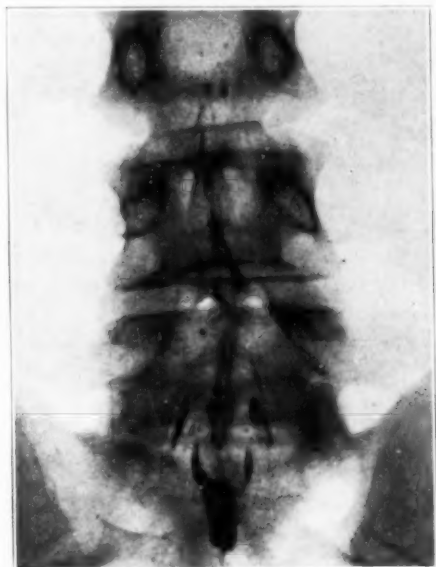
Neuritis of the cauda equina. Roentgenographic appearance of the iodized oil which has fallen to the bottom of the arachnoid sac.
